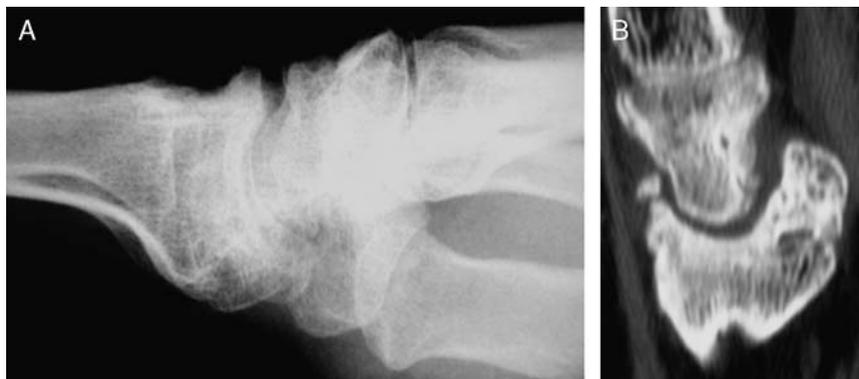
The consolidation of radioscaphoid partial arthrodesis. A, Lateral image of an x-ray. B, A sagittal section of a computed tomography.
